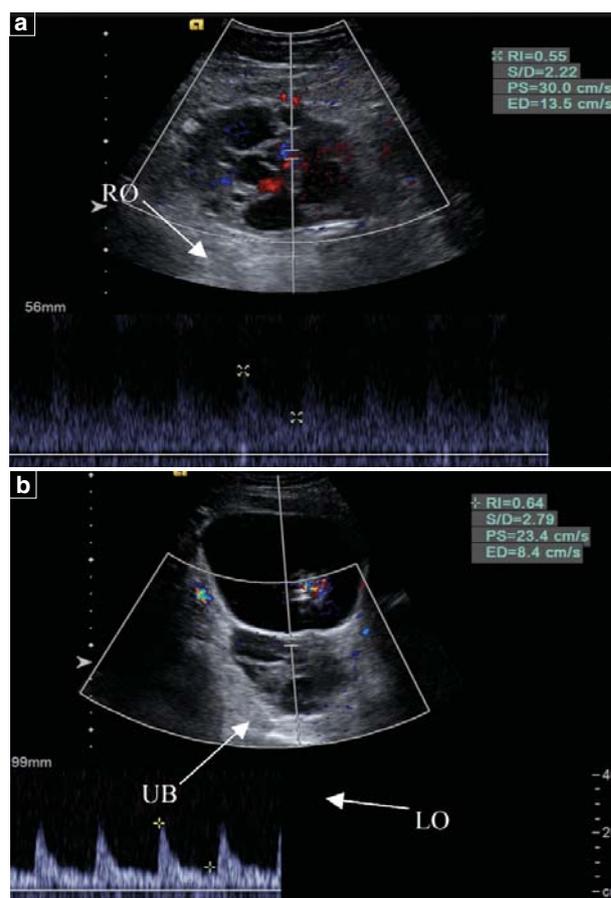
Color doppler ultrasound examination of the right ovarian (RO) parenchyma in [a] shows a relatively increased diastolic flow with an RI of 0.55 indicating an element of ischemia compared to normal arterial spectral waveform and RI in the left ovary (LO) in [b].
